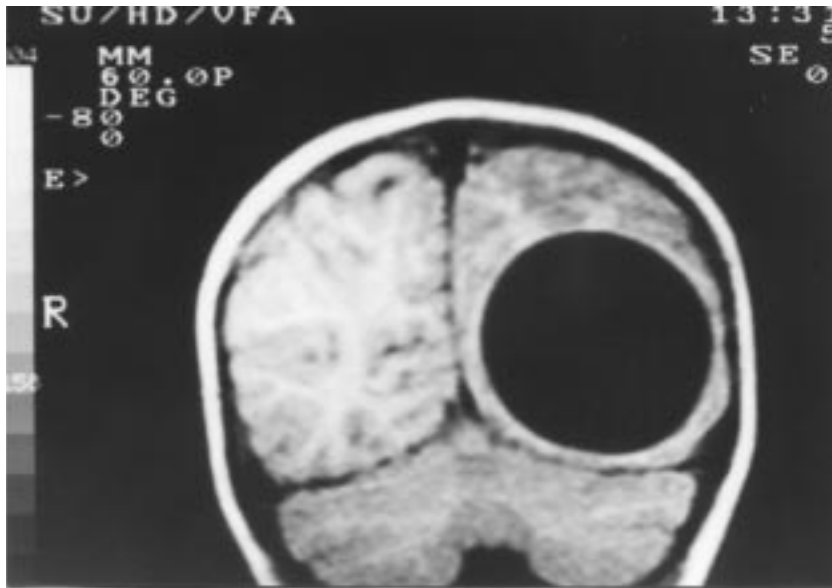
T1-weighted coronary cranial MRI reveals a giant round hypointense cystic lesion localised in the left angular area, 7 x 8 cm in diameter.
